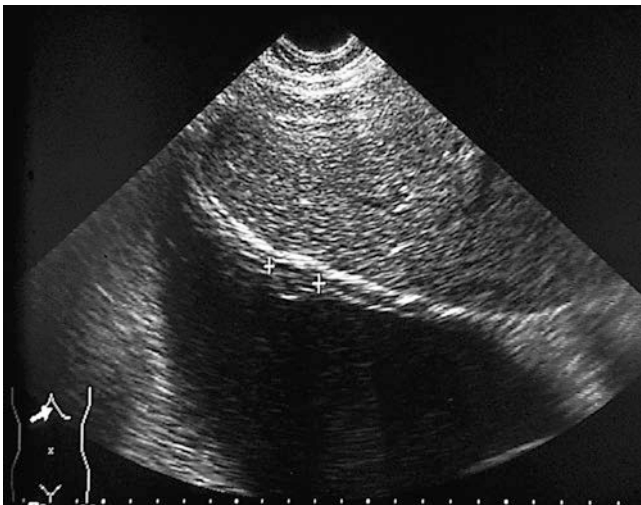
Newly diagnosed mesothelioma spreading tapestry-like nearly over the whole pleura of the right hemithorax, single nodules (between the markers). The patient was admitted to the hospital because of dyspnea within 2 days. In the chest-X-ray a “white hemithorax”. Decade-long asbestos exposition
